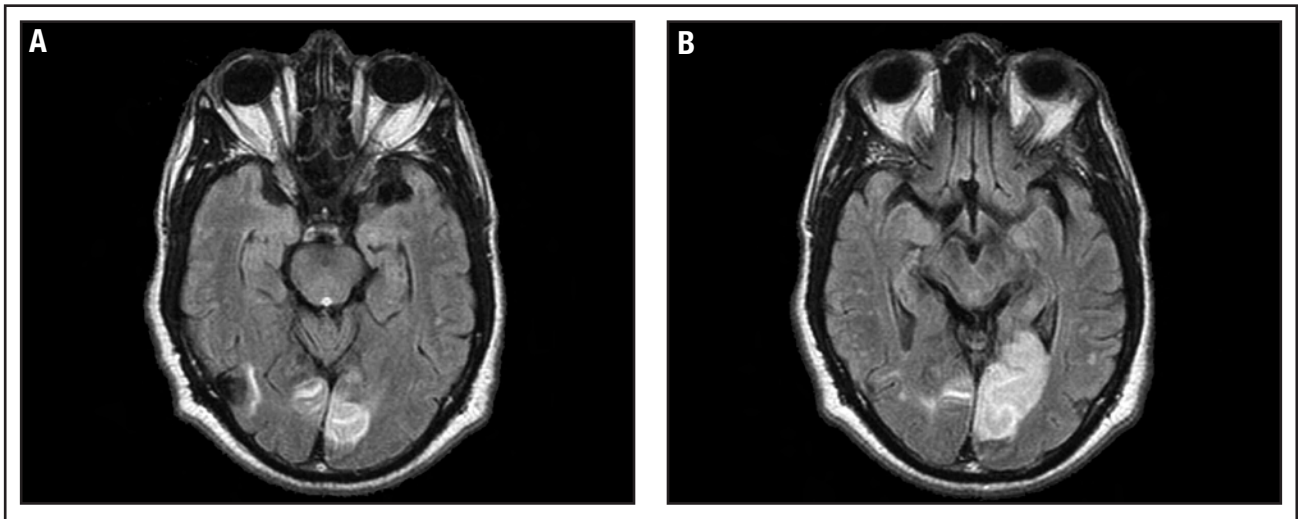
Axial MRI scans showing (A) right and left medial occipital lobe lesions and (B) a more rostral view of the extensive left medial occipital lobe lesion.
